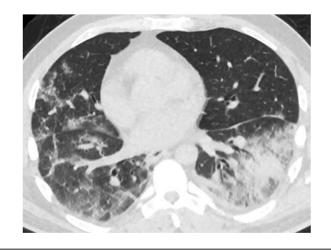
An axial nonenhanced chest computed tomography (CT) image showed patchy ground-glass opacities (GGOs) in the right lung with consolidative lesions in the left lower lobe.
